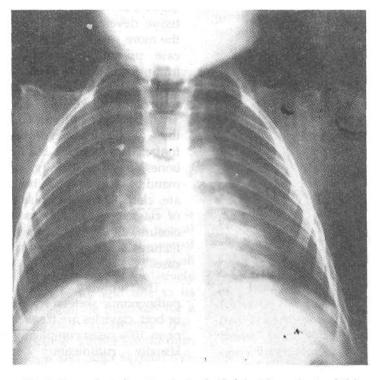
X-ray chest showing missing half of clavicles and spina bifida.
